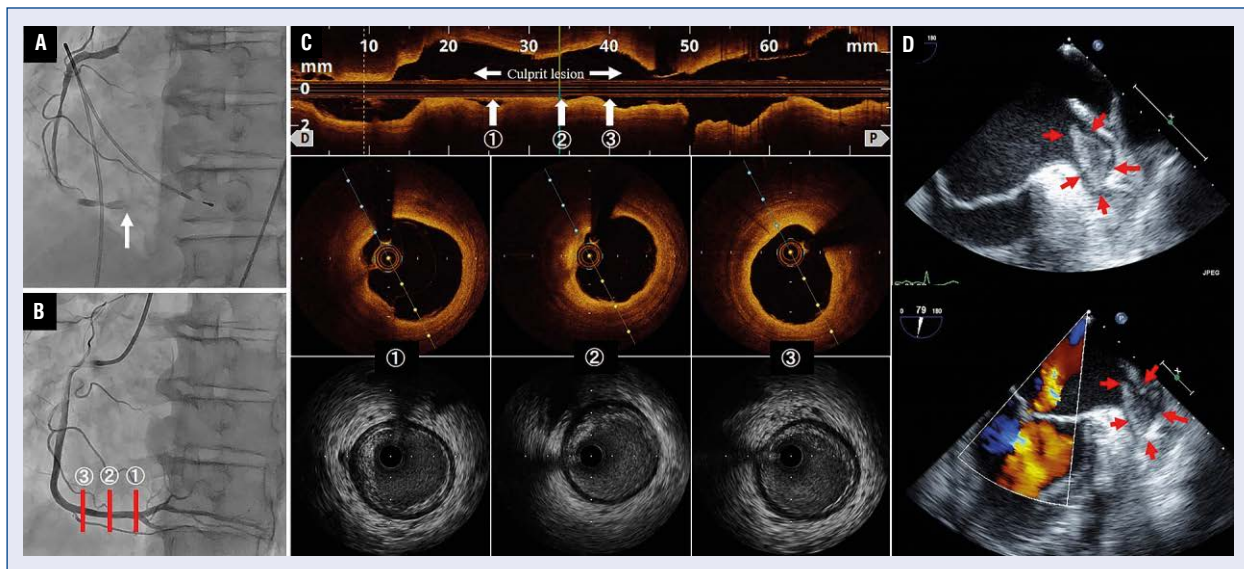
A. Coronary angiography showing an occlusion of the right coronary artery (RCA) (arrow); B. Absence of organized stenosis at the culprit lesion of RCA after recanalization; C. Optical coherence tomography and intravascular ultrasound showing neither evidence of plaque rupture nor erosion at the culprit lesion; D. Transesophageal echocardiography showing the presence of a huge thrombus in left atrial appendage.
